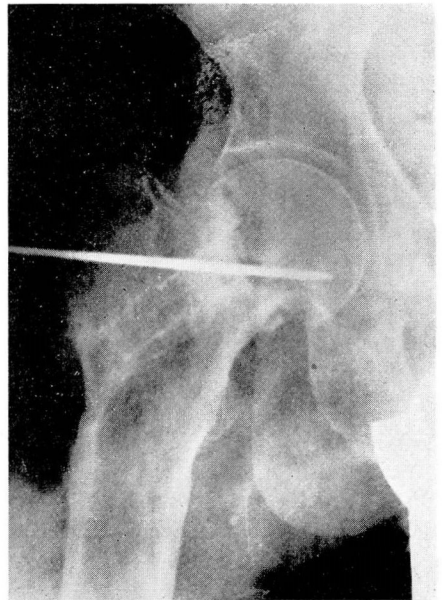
Roentgenogram showing placement of guide wire.
